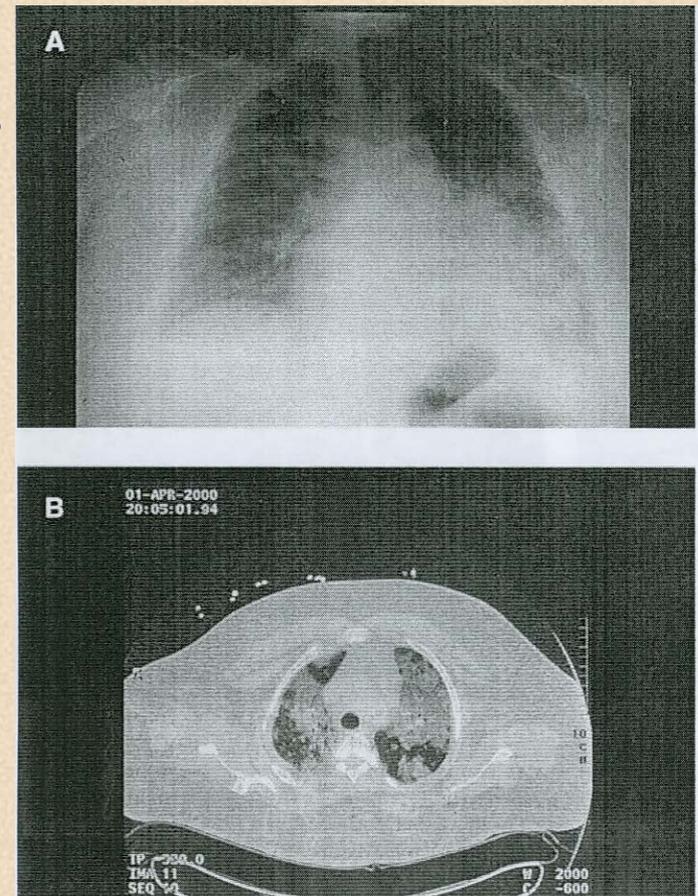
A posteroanterior chest X-ray demonstrated a left lower lobe infiltrate (A). Three days later, both the chest X-ray and CT revealed diffuse opacities (ground glass) throughout both lung fields (B). Two weeks after discharge, the chest X-ray was normal.
